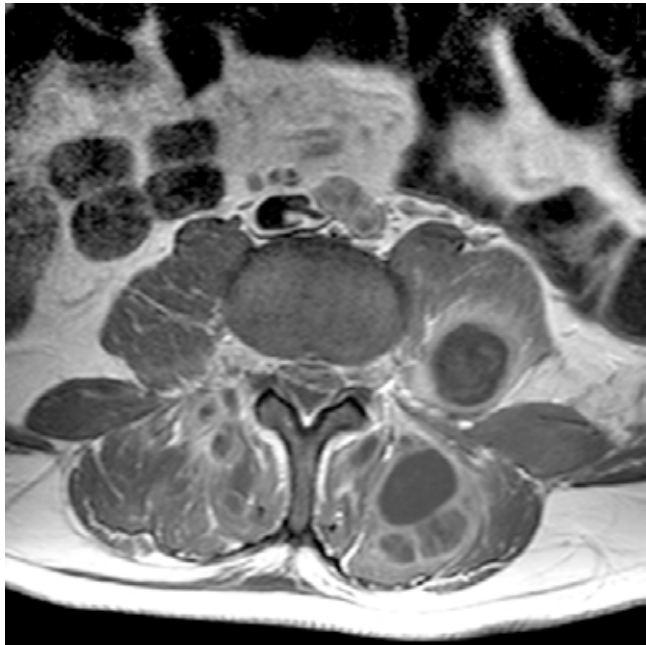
Axial T1-weighted scan of lumbar spine following intravenous Gadolinium, at the time of admission. Note peripherally enhancing epidural and paraspinal abscesses, extending into intervertebral foramina.
